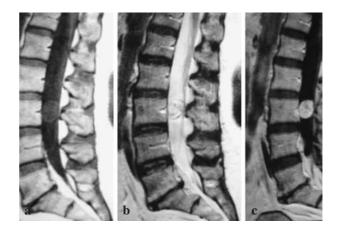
Sagittal T1-weighted image showing a tumour hypointense to normal cord (a). On T2-weighted image the tumour shows some heterogeneity and hyperintensity (b). It enhanced intensely but heterogeneously after contrast administration (c).
